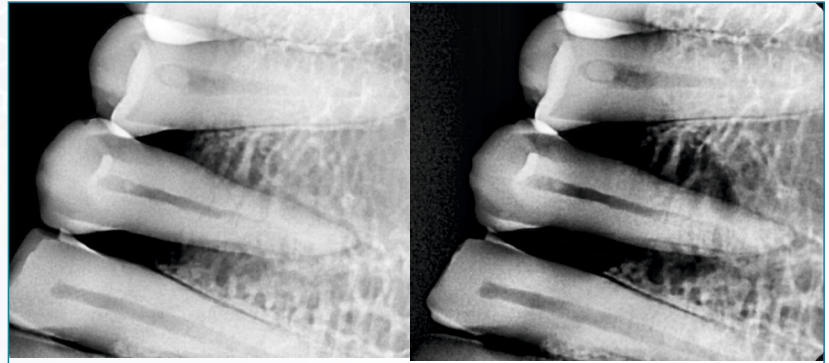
IOPA radiographs at 4-month follow-up, showing vertical bone regeneration at 11 and 35
